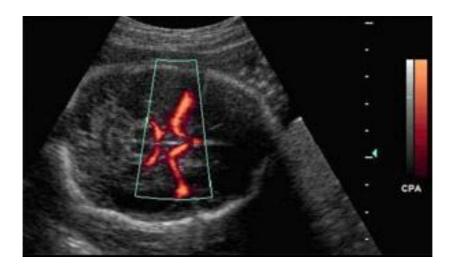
Color Power Doppler of the Circle of Willis
